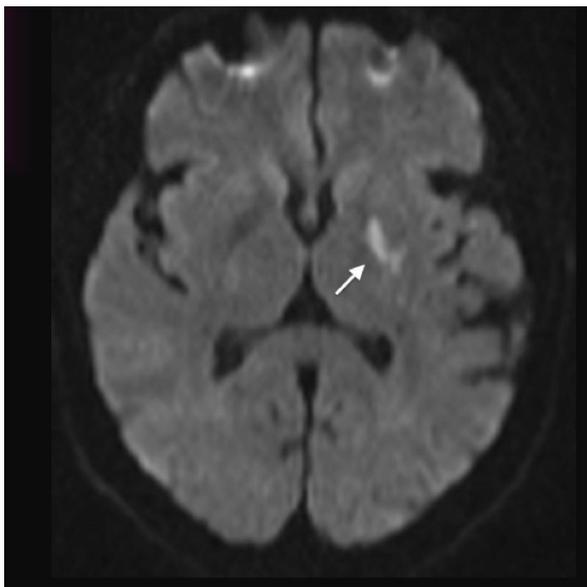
MRI DWI showing a small left sided infarct (white arrow).
